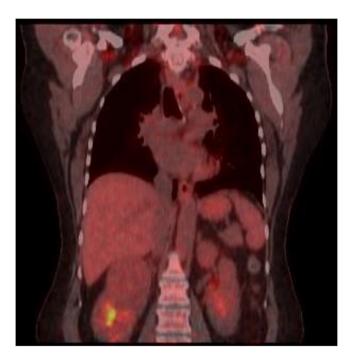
Preoperative PET/CT scan showing the renal lesion.
